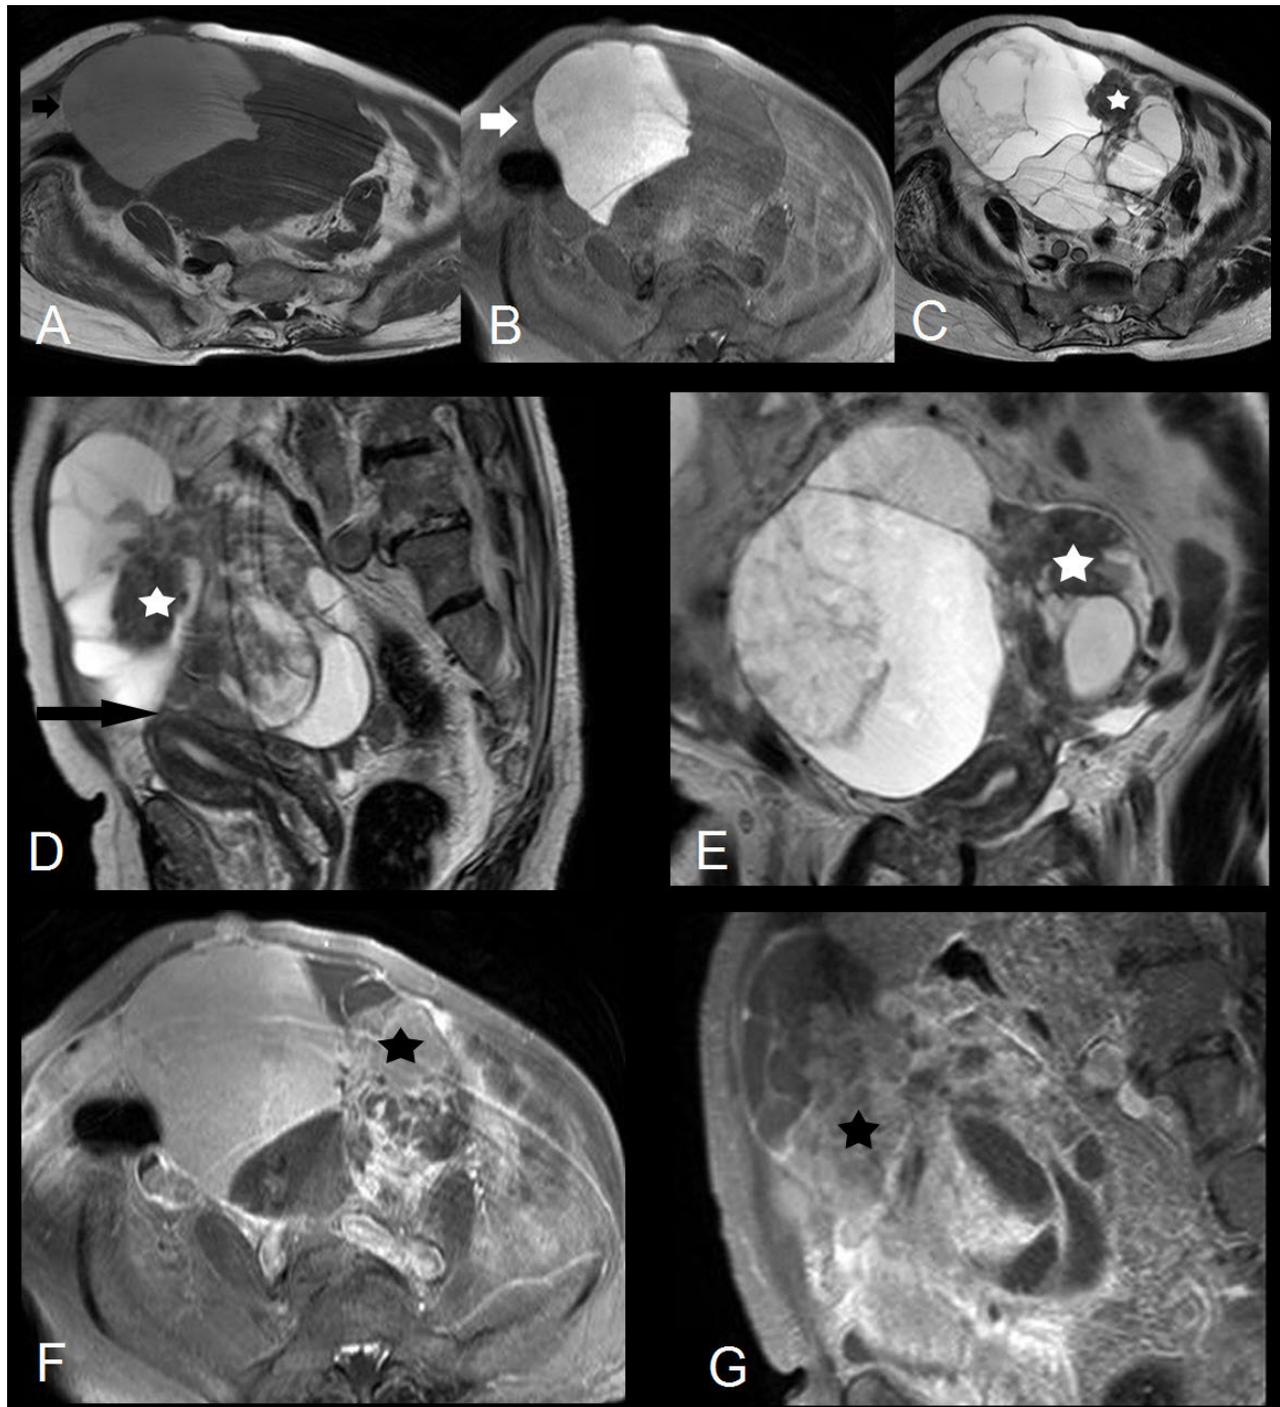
(a) Transverse T1 and (b) fat-suppressed T1-weighted images, (c) transverse, (d) sagittal and (e) coronal T2-weighted images, (f) transverse and (g) sagittal post-contrast fat-suppressed T1-weighted images depict the pelvic mass in close proximity to the uterus (long arrow), containing both cystic and solid parts, the latter contrast-enhancing (asterisk). Hyperintense parts (arrow) on T1-weighted images, proved to correspond to hemorrhagic content on pathology.
